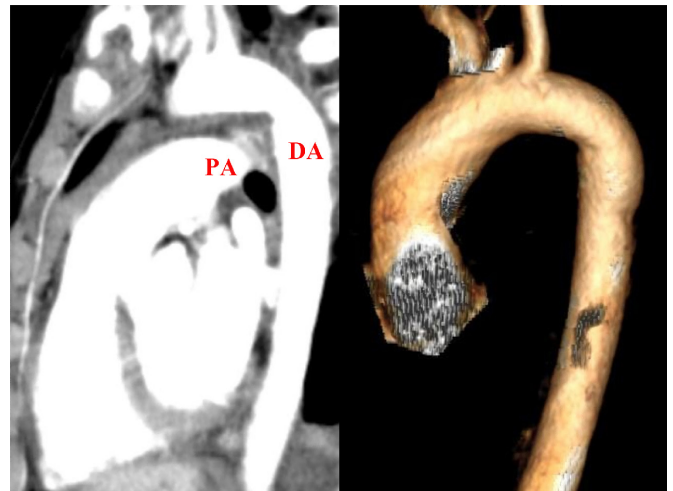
Postoperative computed tomography angiography showed that the aorta was in good condition without obvious stenosis. PA, pulmonary artery; DA, descending aorta
